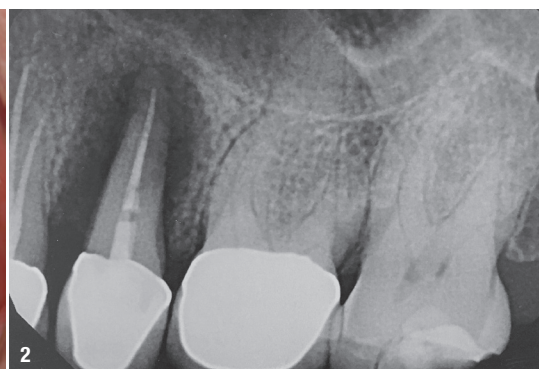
Pre-op buccal view. Fig. 2: Pre-op radiograph. Fig. 3: Full-thickness flap reflection. Fig. 4: Extraction and degranulation. Fig. 5: Membrane stabilised with resorbable sutures over the allograft particulate bone graft.
